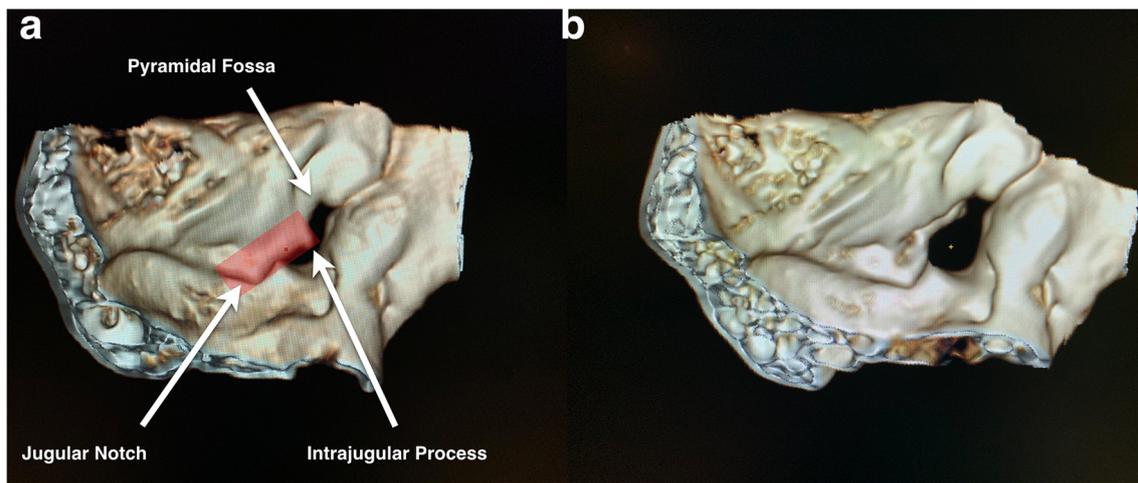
Preoperative (a) and postoperative (b) CT reconstruction showing the extent of resection of the roof of jugular foramen. Note the drilling on the jugular notch and intrajugular process, with almost complete preservation of the pyramidal fossa
